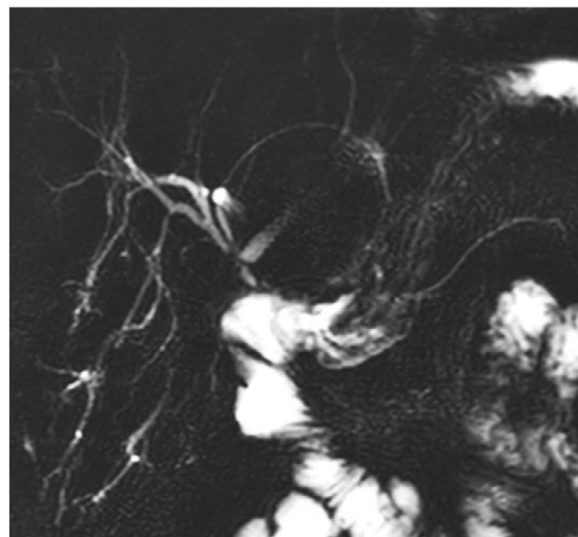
Magnetic resonance imaging cholangiography showing a dilatation of the right biliary.
